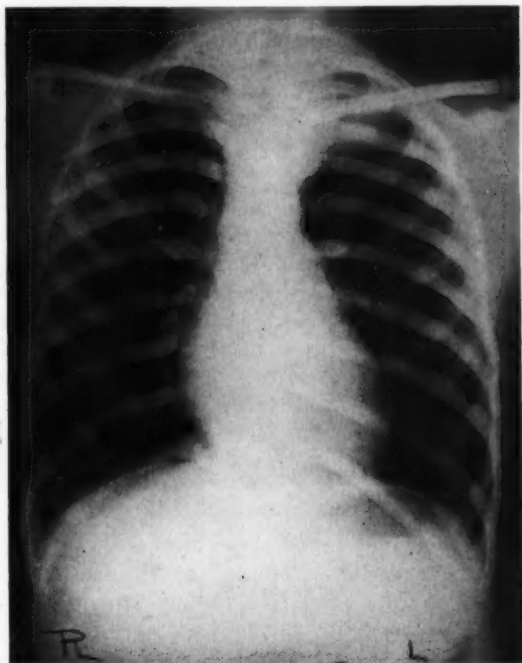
Initial x-ray showing a smooth rounded mass in the area of left upper mediastinum.
